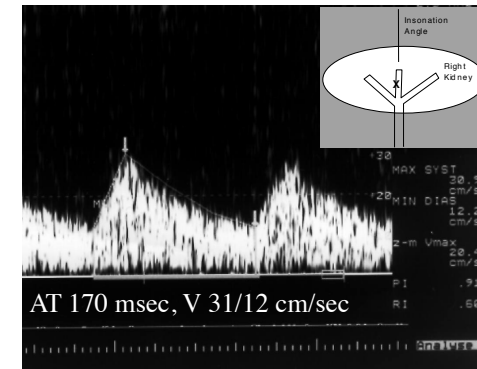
Dopplerspektren bei verschiedenen Stenosegraden. Die Pfeile bedeuten die Meßpunkte der Akzelerationszeit (AT).
